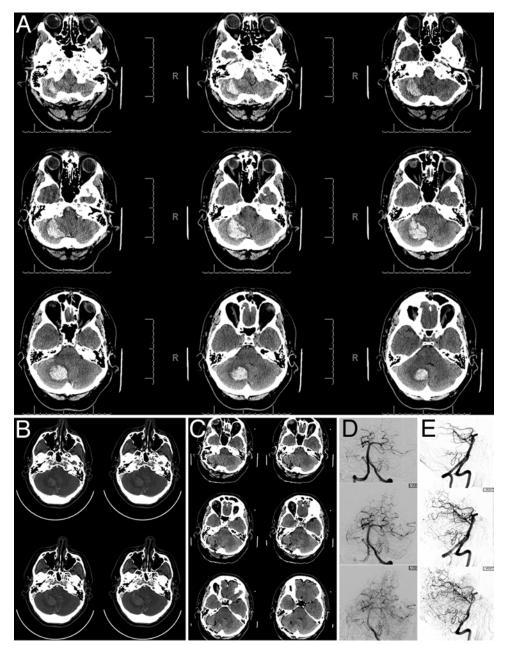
Images obtained in a 43-year-old man with no prior medical history, who awoke with headache, nausea, and dizziness, and whose blood pressure was 109/54 mm Hg. A: Axial CT scans without contrast demonstrate a large hemorrhage of the right cerebellar hemisphere. B: Because of the patient's young age and lack of hypertension, a high suspicion for an underlying structural lesion led to the performance of a CT angiogram, which demonstrates an abundantly prominent collection of vessels suggesting a possible AVM. In retrospect, however, this finding was found to merely represent compression of normal vessels by the mass effect of the bleed. C: Axial CT scan after surgical evacuation of the hemorrhage reveals no further mass effect. D: Frontal view of a vertebral artery catheter angiogram confirms the absence of an underlying AVM. E: Lateral view of a vertebral artery catheter angiogram confirms the absence of an underlying AVM.
